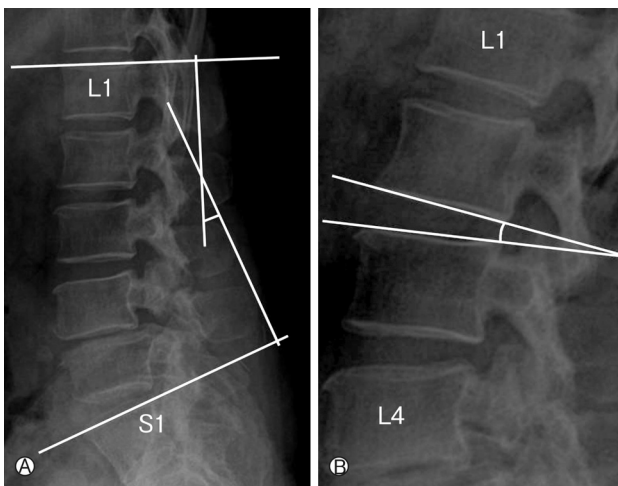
Sagittal angle measurement by Cobb's angle method on plain X-ray. A: To measure the lordotic angle, line along the superior end plate of the L1 body and line along the superior end plate of the S1 body were drawn. Then, lines perpendicular to each line are drawn. The angle between two perpendicular lines was a lumbar lordotic angle. B: Segmental angle accounted for flexion-extension angle between fused segment and cranial or caudal adjacent segment. To measure it, line along the end plate of adjacent vertebra body and line along the end plate of the most superior or inferior fused vertebra body were drawn. The angle between two lines was an adjacent segmental angle.
